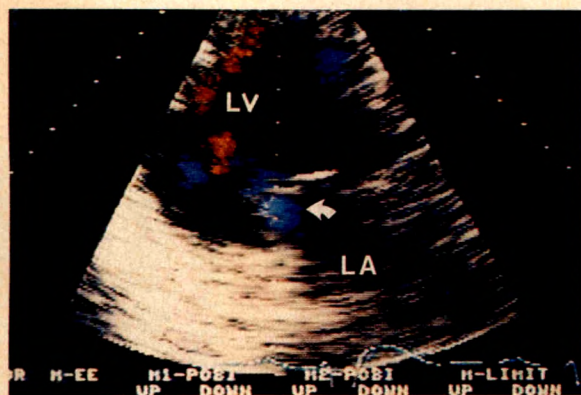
Mitral regurgitation (white arrow) coincident with the B bump of the mitral valve on a 2-dimensional color Doppler echocardiogram. Blue signals (white arrow) suggest regurgitant mitral flow because they are observed to travel from the mitral valve orifice into the left atrium (LA). LV = left ventricle.
